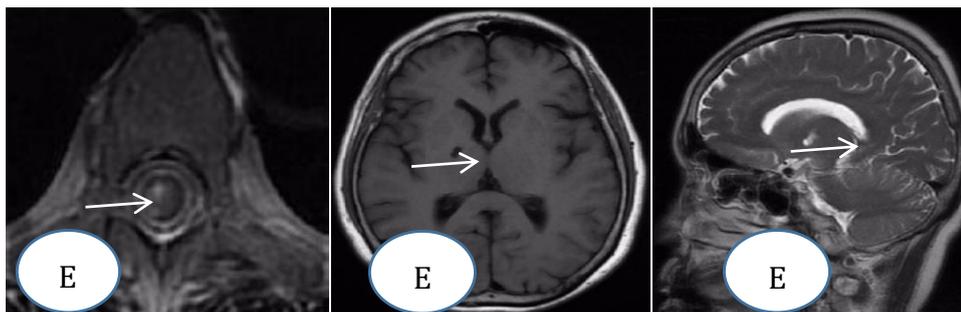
Figure E ((the late-onset patient) (April 2020): E1, STIR high signal of thoracic spinal cord cross-section. E2, FLAIR low signal surrounding ring high signal in head. E3, Long T2 signal of head sagittal.
